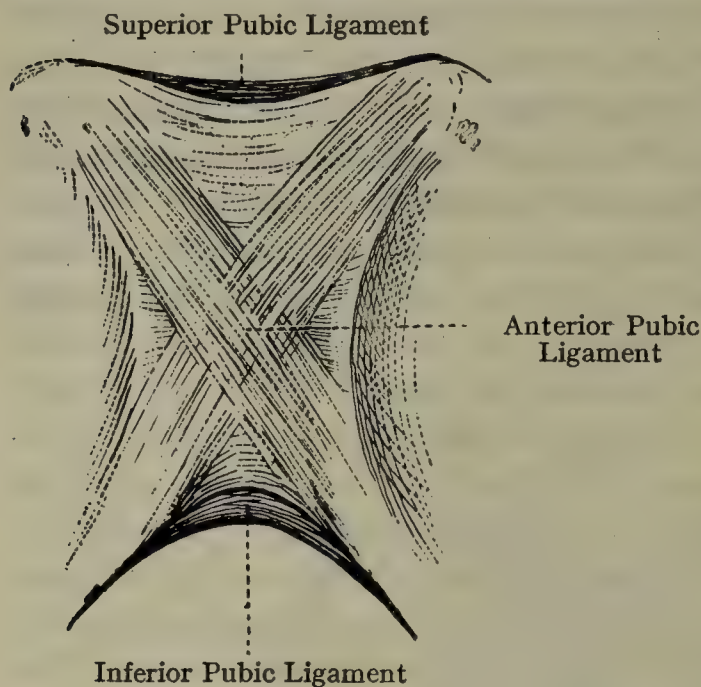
THE LIGAMENTS OF THE SYMPHYSIS PUBIS (ANTERIOR ASPECT).
